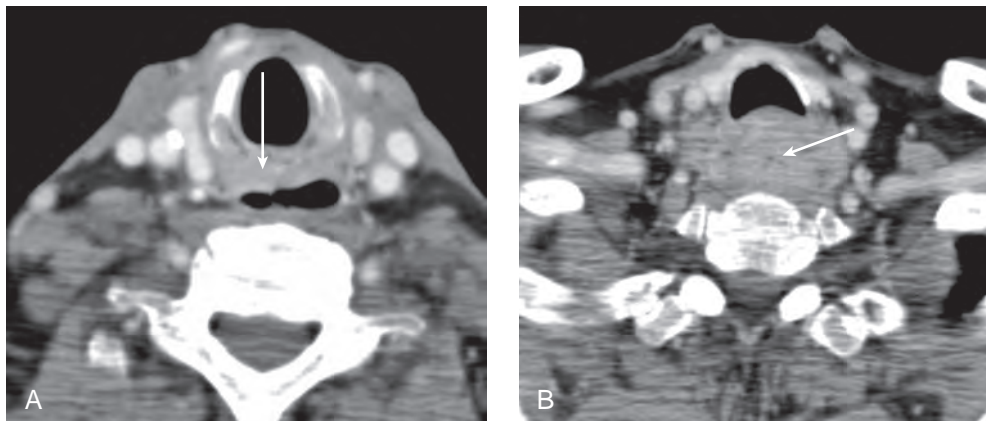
A contrast-enhanced computed tomography scan showing (A) a locally advanced tumor of the right pyriform sinus that has (B) destroyed the posterior aspect of the lamina of the right thyroid cartilage and (C) the right half of the cricoid cartilage with obvious extralaryngeal soft-tissue extension.
